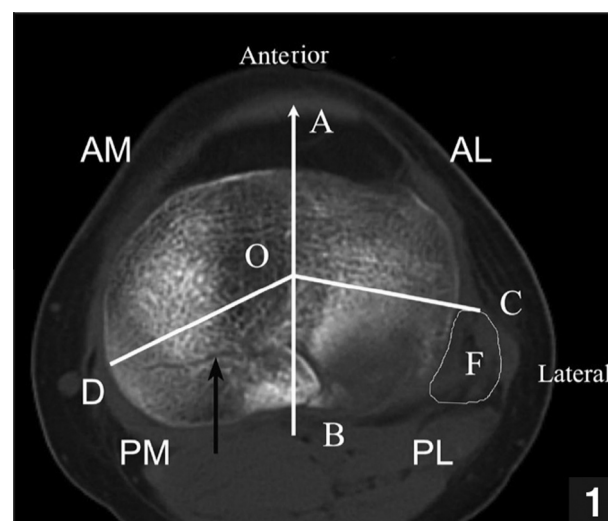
Axial computed tomography scan at the subchondral level showing a posterolateral (PL) articular fragment. Point O is the center of the knee (midpoint of 2 tibial spines), point A is the anterior tibial tuberosity, point B is the posterior sulcus of the tibial plateau, point C is the most anterior point of the fibular head (F), and point D is the posteromedial (PM) ridge of the proximal tibia. Although a fracture line exists in the posteromedial quadrant (black arrow), the posteromedial cortex remains intact and a posteromedial fracture was excluded. Abbreviations: AL, anterolateral; AM, anteromedial (5).
